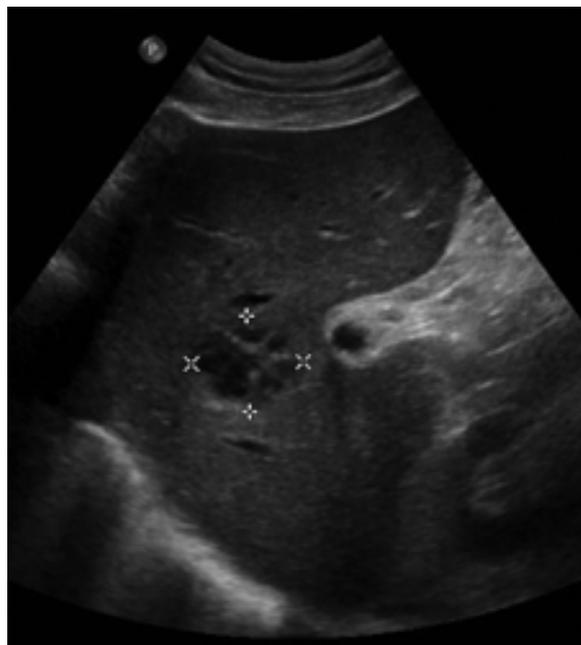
Abdominal ultrasound showing a 3.3-cm abscess in the eighth segment of the liver.
